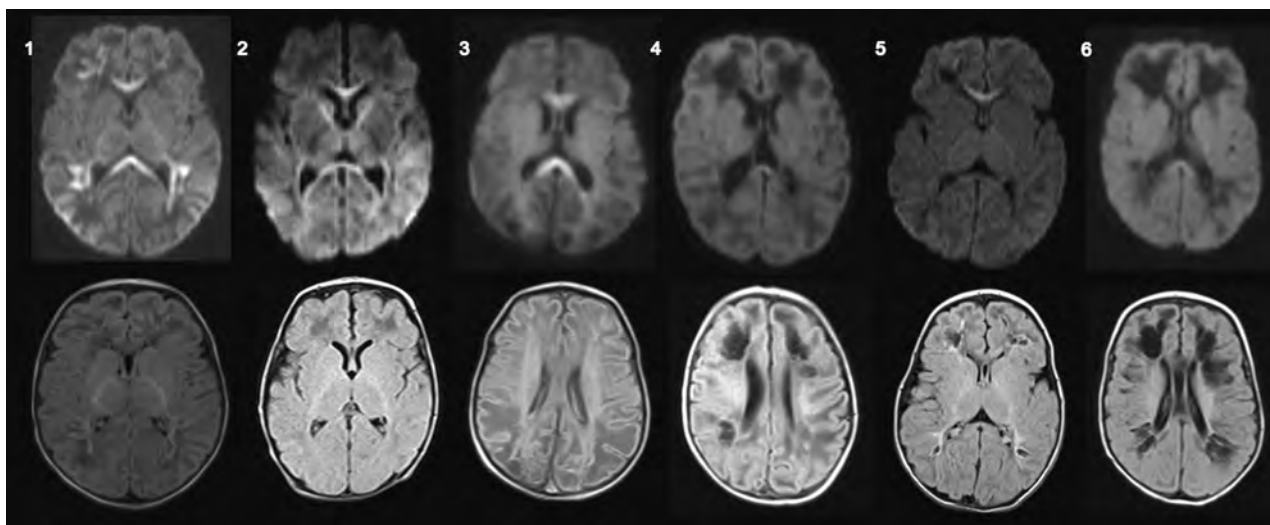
Brain MR imaging of 6 infants with confirmed perinatal CHIKV infection. Axial diffusion-weighted imaging (*upper row*) and axial FLAIR (*lower row*) of patients 1–6. Patients who underwent MR imaging before 14 days of symptom onset presented with restricted diffusion in the corpus callosum and/or subcortical white matter with a perivascular distribution, whereas patients who underwent MR imaging after 14 days of symptom onset presented with subcortical cystic lesions, also with a perivascular distribution with discrete restricted diffusion in the corpus callosum.
